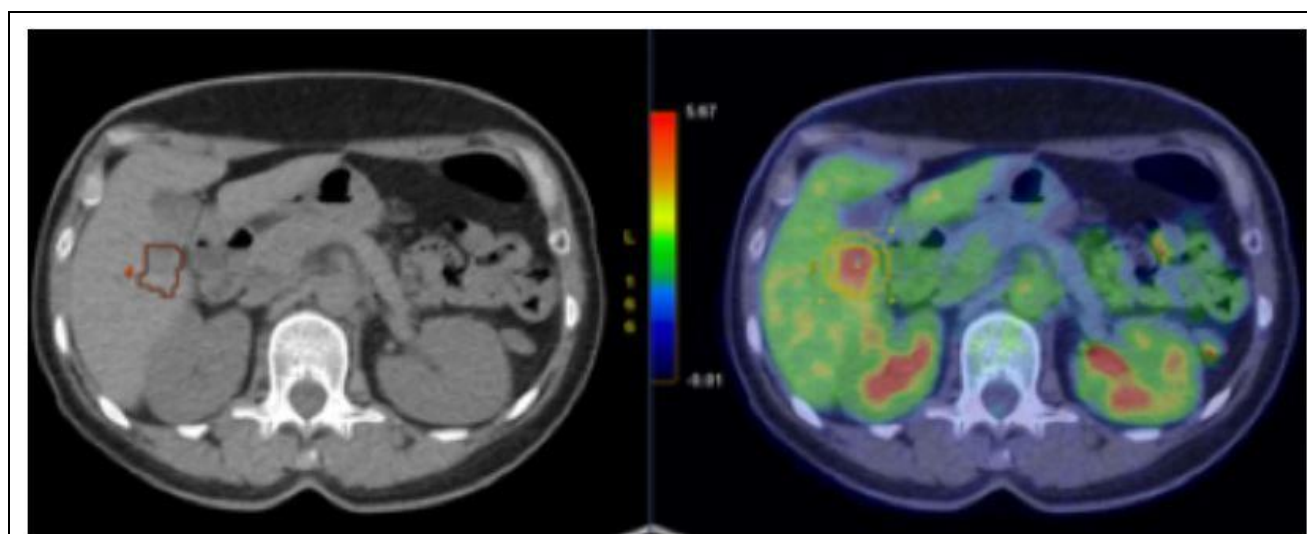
Liver lesion found at the CT.
